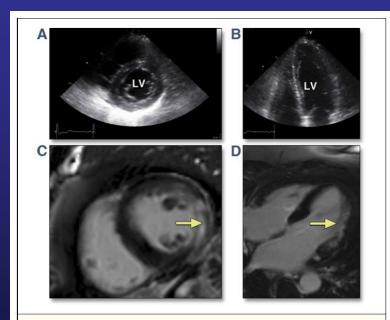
Echocardiographic and CMR Images of a Female Patient Without LV Hypertrophy but With LE
